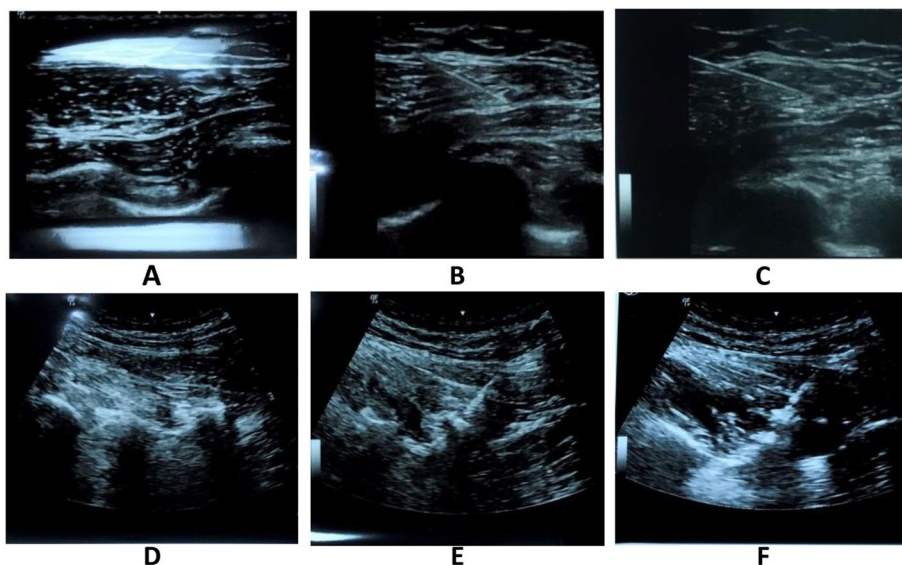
It was added separately due to size. Figure shows both interventions: First, the ultrasound-guided PECS II block (A) Pre-injection, (B) Needling, and (C) Injection of the local anesthetic, then the ultrasound-guided ESP block (D) pre-injection, (E) Needling, and (F) Injection of the local anesthetic
